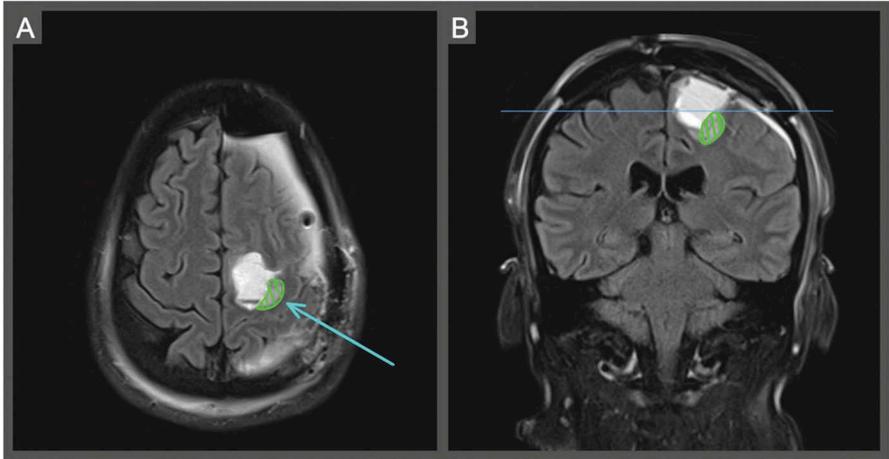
Post-operative axial and coronal views. The left and right images are T2-weighted fluid-attenuated inverted recovery (FLAIR) axial and coronal (respectively) MR images from the patient's post-operative course. In comparison to his pre-operative imaging, an area of the intentional residual is noted at the inferior lateral margin. The resected volume is marked by a signal more intense (brighter) as compared to the residual, which is in close proximity to the motor cortex (arrow).
